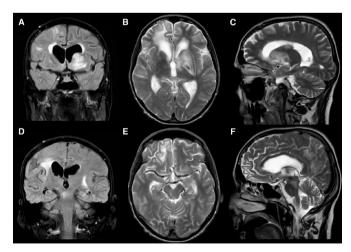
Repeated MRI analysis. MRI performed 3 months after hospital admission showing new hyperintense lesions with swelling in the left basal ganglia (A: coronal view FLAIR imaging; B: axial T2 imaging and C: sagittal T2 imaging), midbrain and around the right-sided gliosis (D: coronal view FLAIR imaging; E: axial T2 imaging and F: sagittal T2 imaging). FLAIR, fluid-attenuated inversion recovery.
